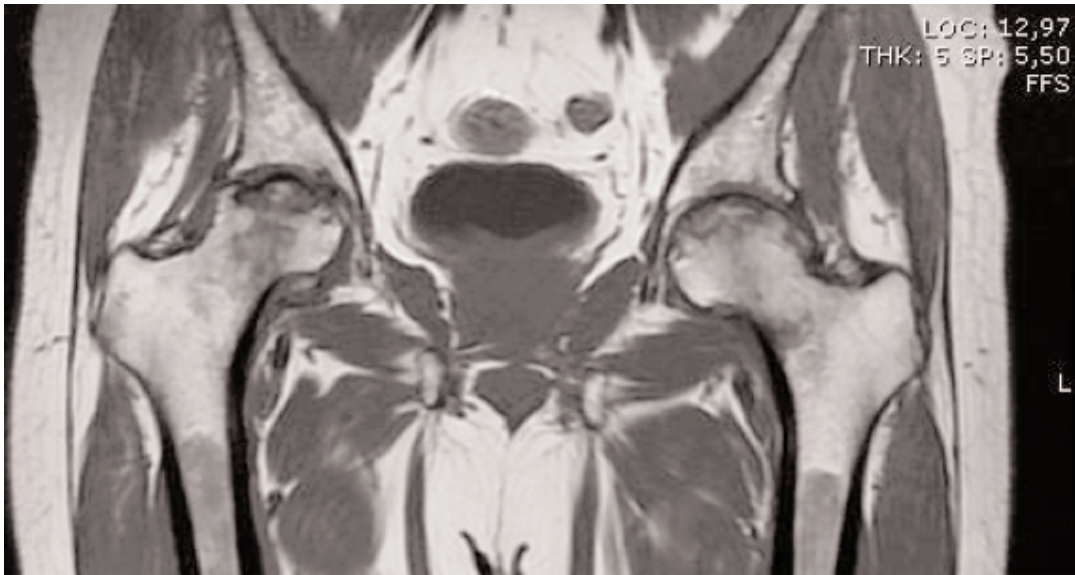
Coronal MRI scan highlights bilateral necrosis areas.
